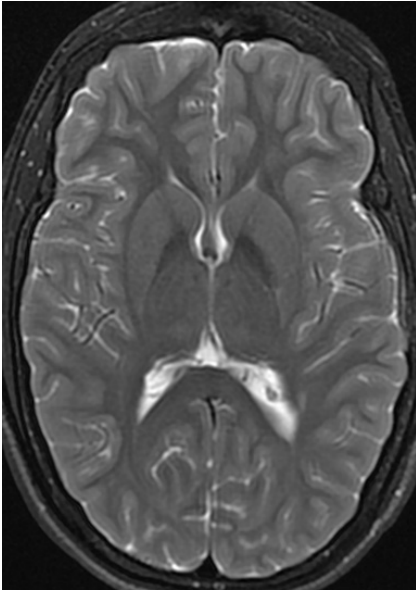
15-year-old male with GLUT1 deficiency syndrome and absence epilepsy. Although GLUT1 deficiency can be associated with cerebral atrophy, this patient's MRI is structurally normal.
